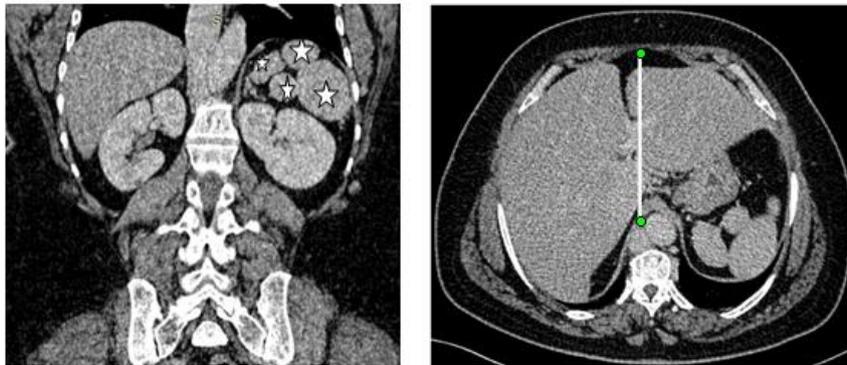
Contrast enhanced CT in coronal and axial sections showing four spleens different in sizes with an unusually medial falciform ligament
